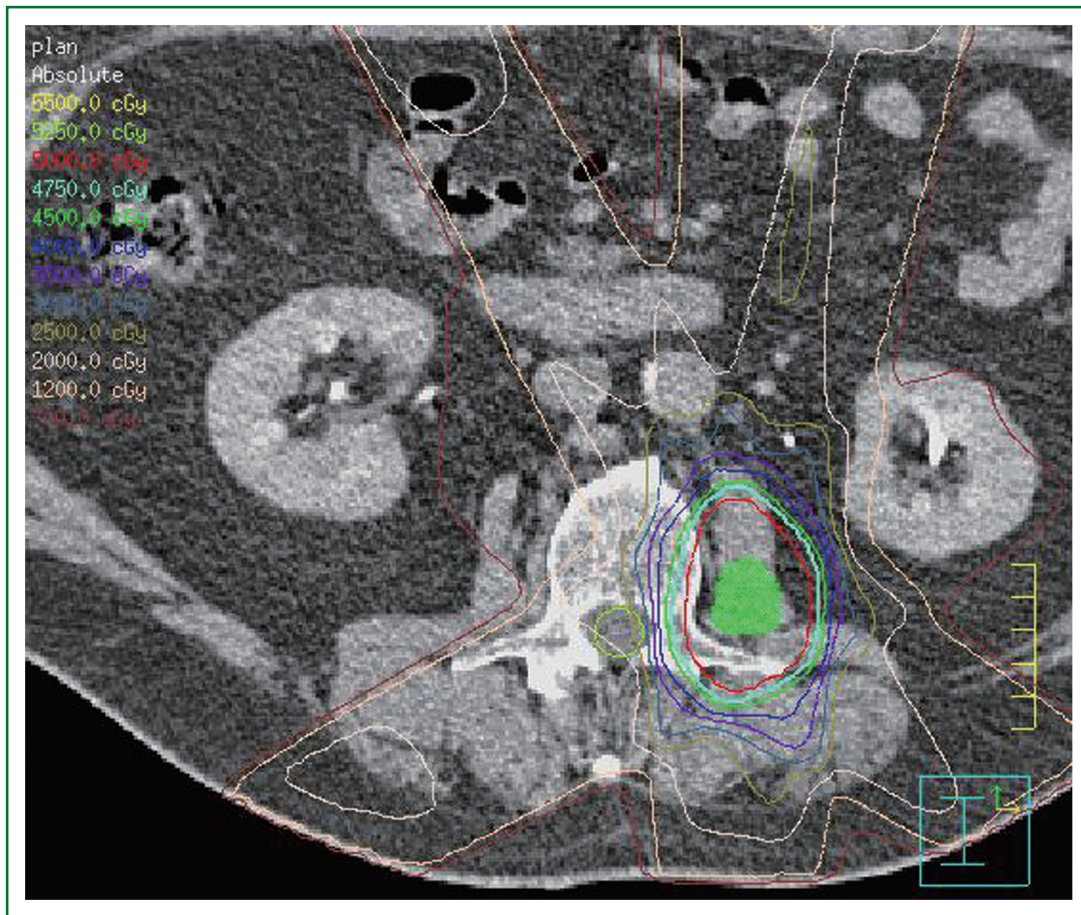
An axial section of the treatment planning CT scan. The green colorwash represents the gross tumor. Radiation isodose lines are described in the key in the upper left.
